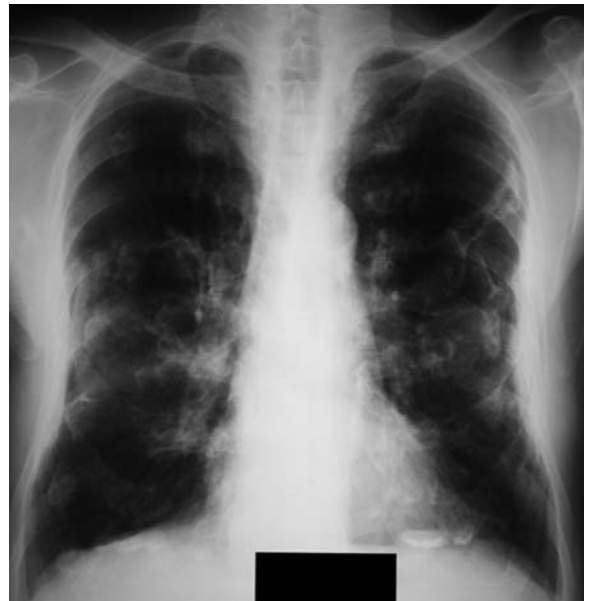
Postero-anterior chest radiograph shows calcified pleural plaques appearing as bilateral dense opacities
